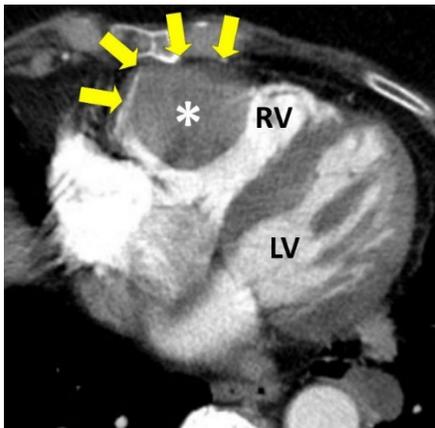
Contrast-based Chest CT. Axial view showing a voluminous round-shaped mass (white asterisk) expanding within the right ventricular cavity (arrows). RV: right ventricle; LV: left ventricle.
